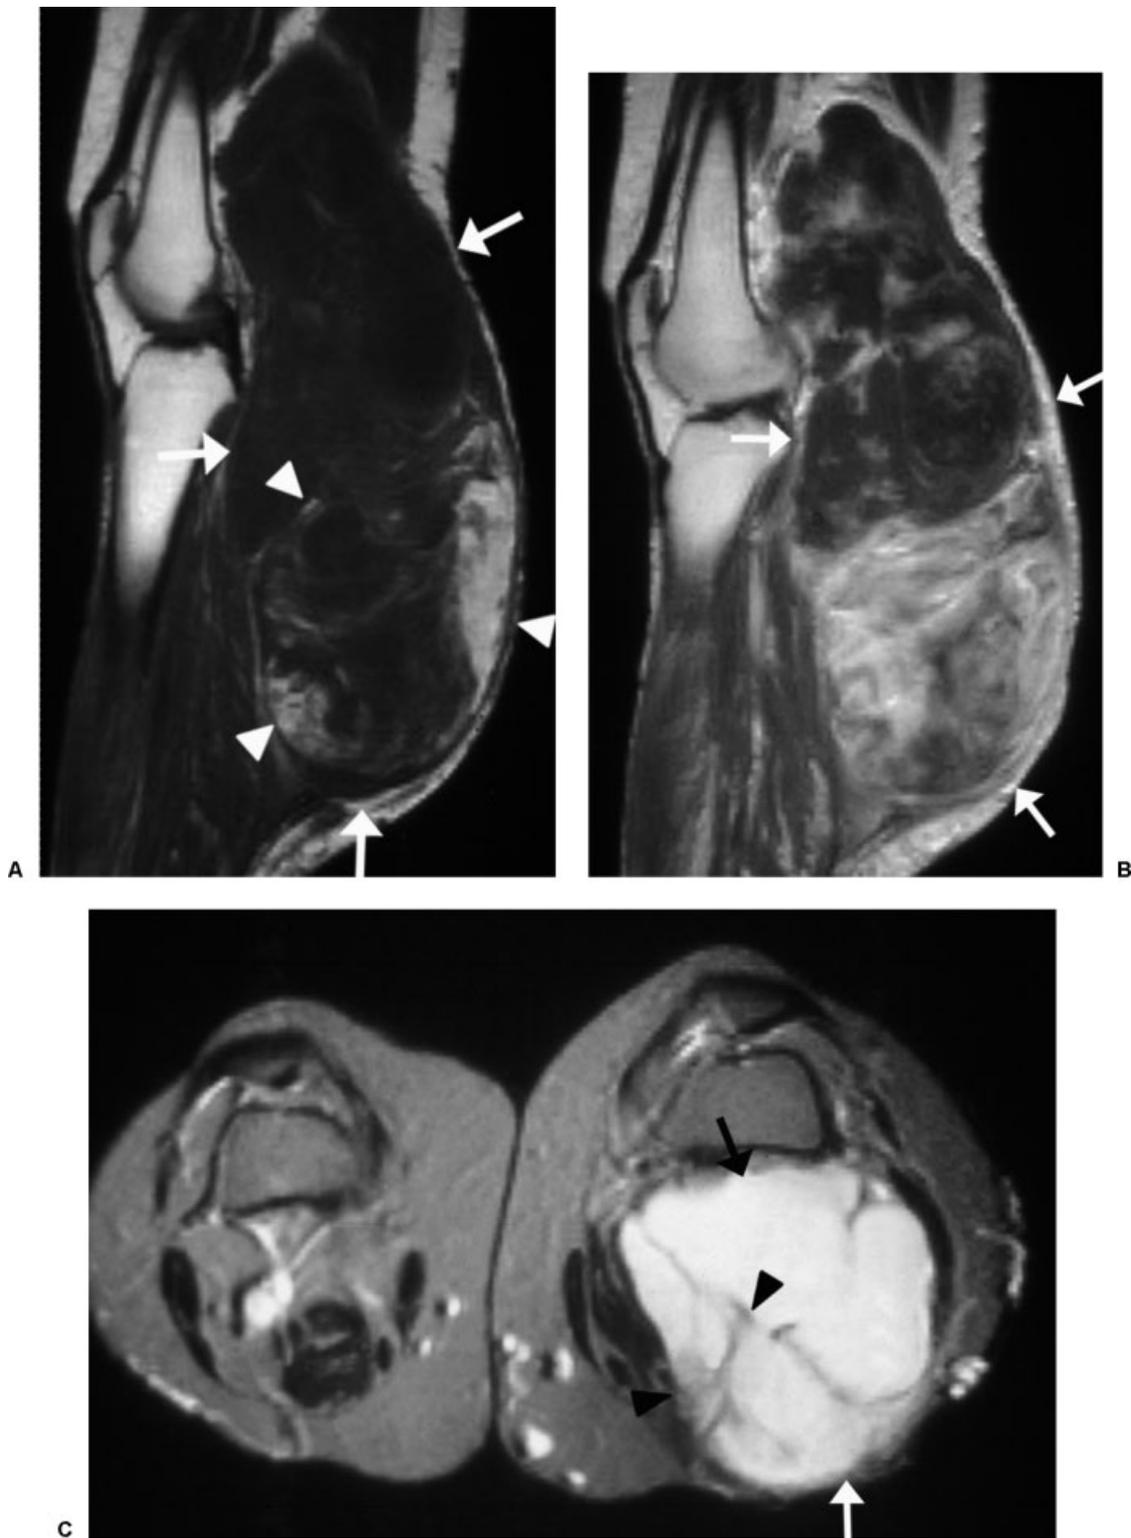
Myxoid liposarcoma of the popliteal region in a 60-year-old woman with a painless, slowly enlarging mass. (A–C) Sagittal T1-weighted (A, 500/20) MR images both (A) before and after (B) intravenous contrast and axial T2-weighted (C, 2500/90) MR images show a large heterogeneous intermuscular popliteal mass (arrows). The predominant signal intensity is that of a high water content mass with low signal on T1 weighting and high signal on T2 weighting. However, focal areas in the septae and several small nodular regions (arrowheads) (< 10% of the tumor volume) are isointense to subcutaneous fat. Following contrast administration there is thick and nodular peripheral and septal enhancement most prominent inferiorly.
